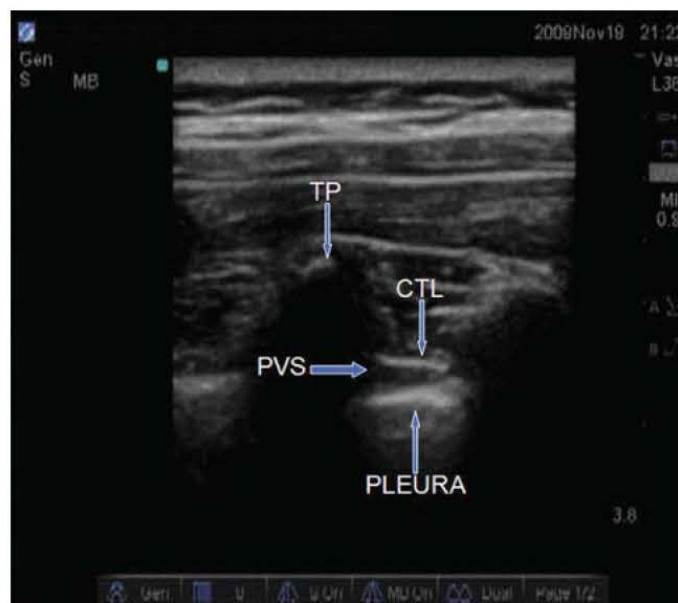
Ultrasound scan of the posterior chest wall showing the TP, costotransverse ligament (CTL), paravertebral space (PVS), and pleura (Karmakar, 2001).
